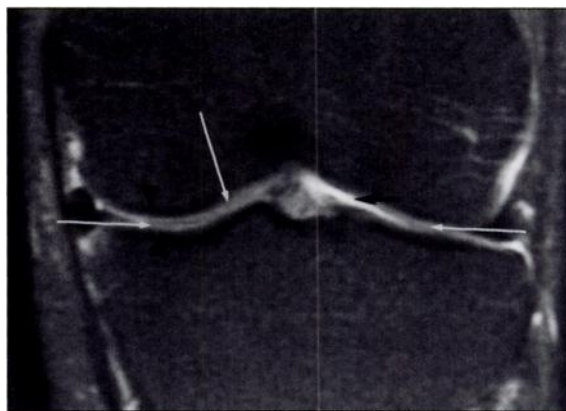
35-year-old man with normal articular cartilage. Coronal T2-weighted fast spin-echo image with fat saturation (TR/TE, 3000/38) shows intermediate signal intensity of normal articular cartilage (white arrows) that can be easily differentiated from high signal intensity of joint fluid (black arrow) and low signal intensity of subchondral endplate (arrowheads).
